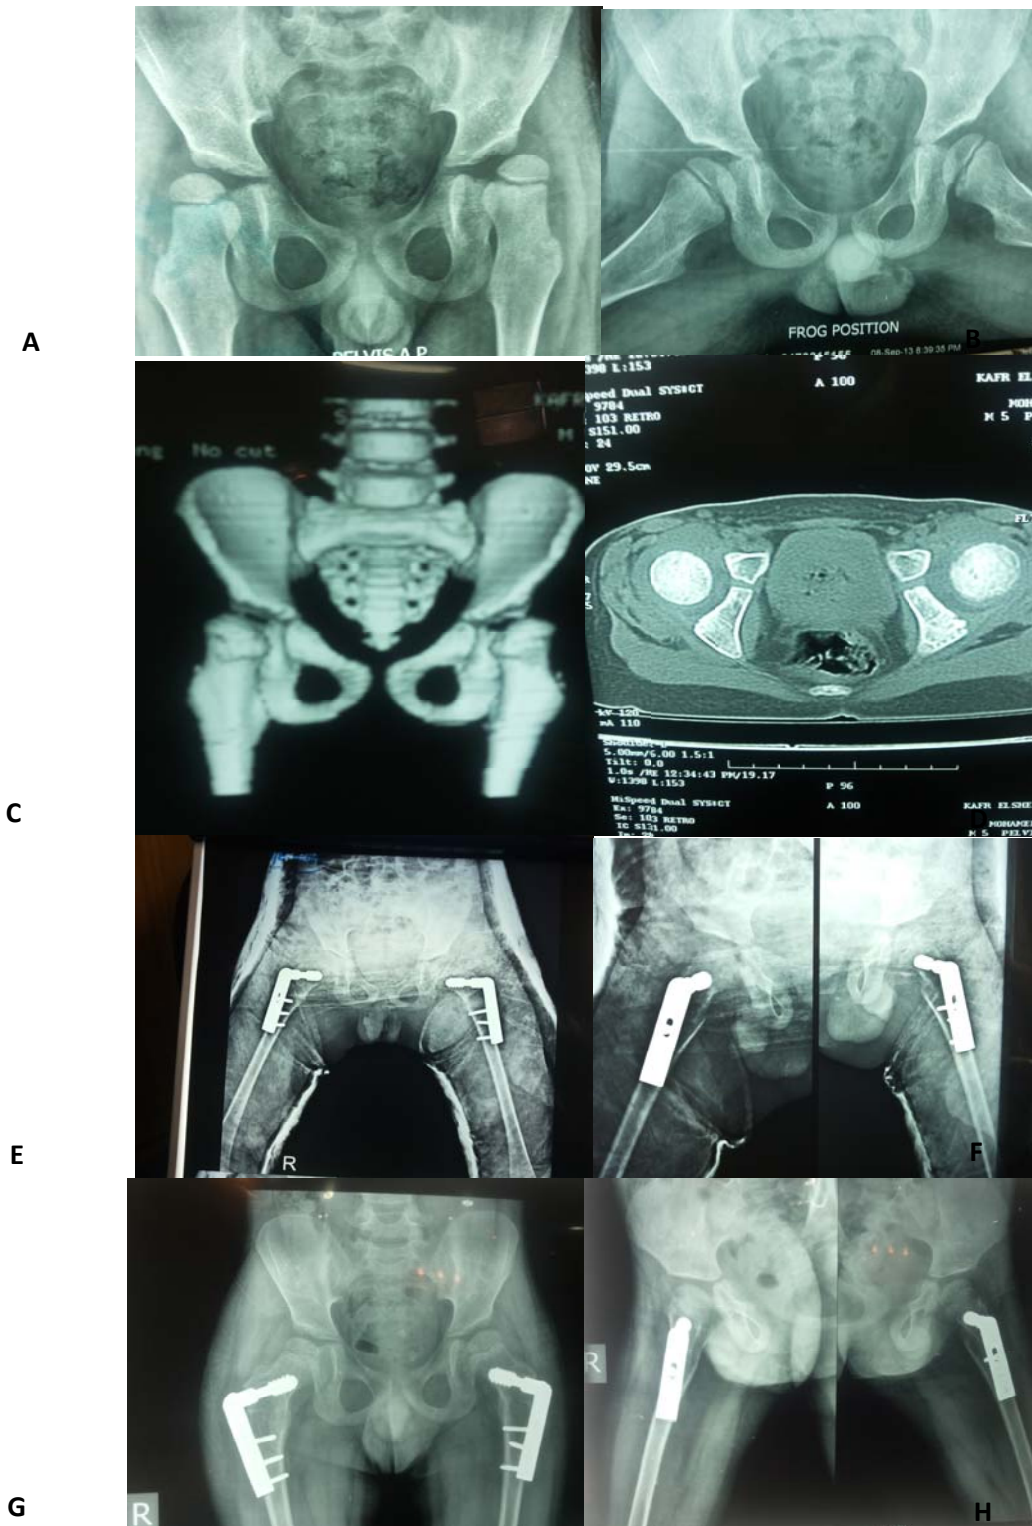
(A & B) : preoperative AP/ Lateral View, (C & D) : preoperative CT (E & F) : Immediate Postoperative X-Rays, (G & H) : 6-Months Postoperative X-Rays
